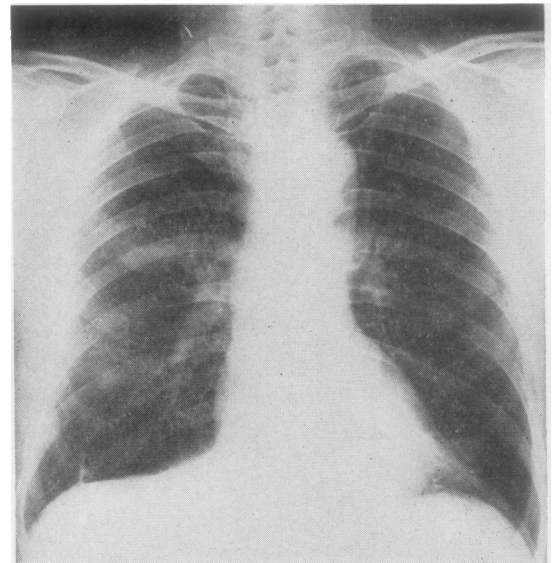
H.W.: Radiograph taken on April 3, 1957, showing an opacity in the apex of the right lower lobe.
